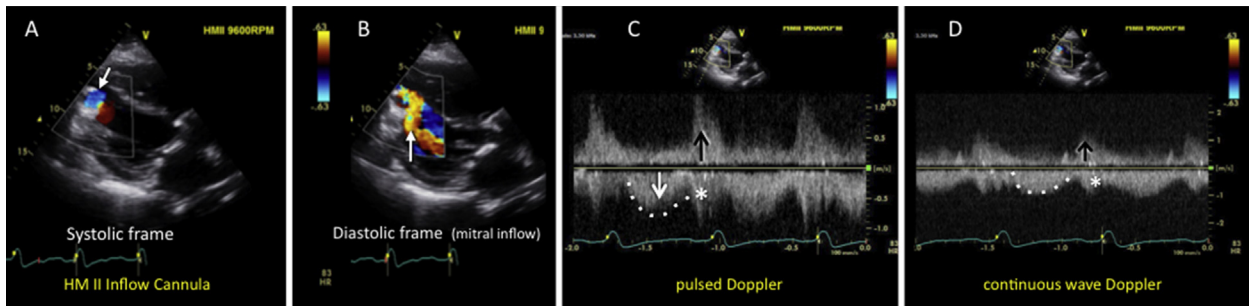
(A) HM-II inflow cannula, systolic frame, showing normal color Doppler inflow (blue, downward arrow). (B) HM-II inflow cannula, diastolic frame, with color Doppler showing prominent diastolic mitral inflow (orange, upward arrow) in a patient with a previous mitral annuloplasty repair. See also [Video 28](#). (C) Pulsed Doppler examination of the inflow cannula shows normal systolic inflow (dotted line). However, prominent bidirectional diastolic velocities are present due to mitral inflow (arrow) and interaction between the cannula and the adjacent interventricular septum (*) (see moving image). (D) Continuous-wave Doppler shows a similar pattern and rules out obstruction. Note: Hybrid/contaminated inflow-cannula Doppler signals may also be observed with AR jets. These types of low-velocity, normal-variant, contaminated inflow-cannula spectral Doppler patterns can be explained with color Doppler and should not be confused with higher-velocity signals (typically >2 m/sec), which could signify inflow obstruction. Nonetheless, the pure continuous diastolic inflow, as shown in [Figure 19](#), is not seen, and the diastolic nadir velocity cannot be reported.
